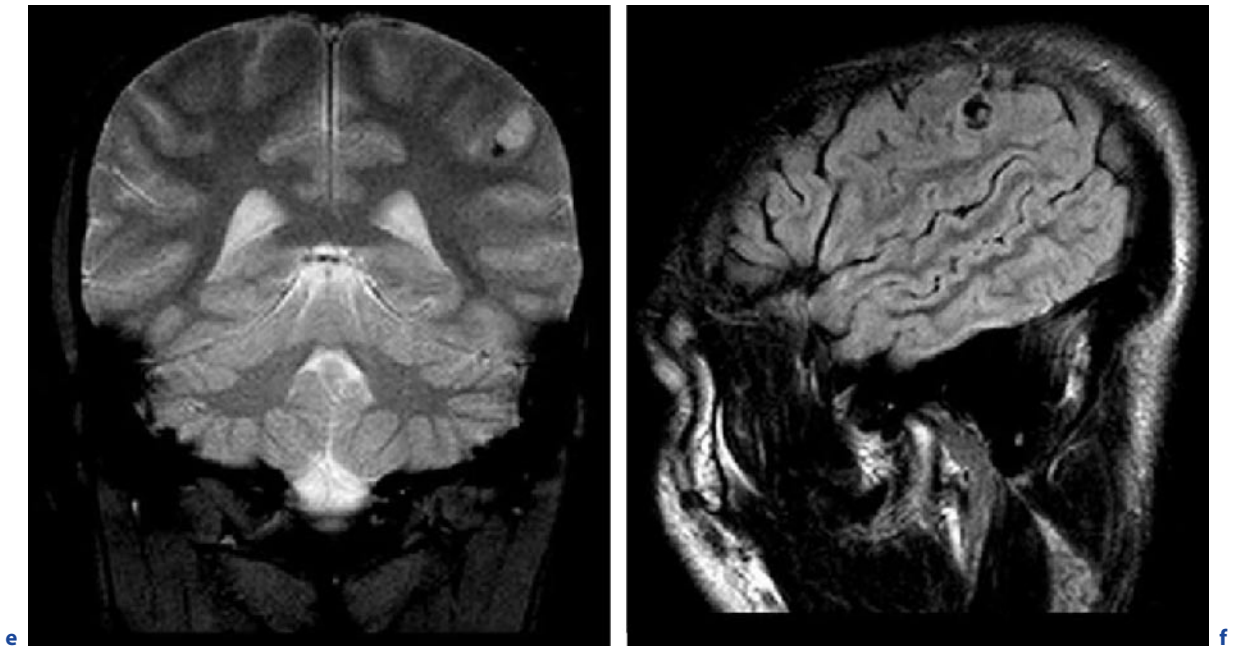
(continued) Neurocysticercosis in a 22-year-old man. a Axial T2-weighted image. e Coronal T2*-weighted image. f Sagittal FLAIR image. The solitary cysticercus has a classical localization in the subarachnoid space over the convexity, in this case the left postcentral sulcus. The lesion is fluid-filled resembling CSF, and appears hyperintense on T2-weighted
